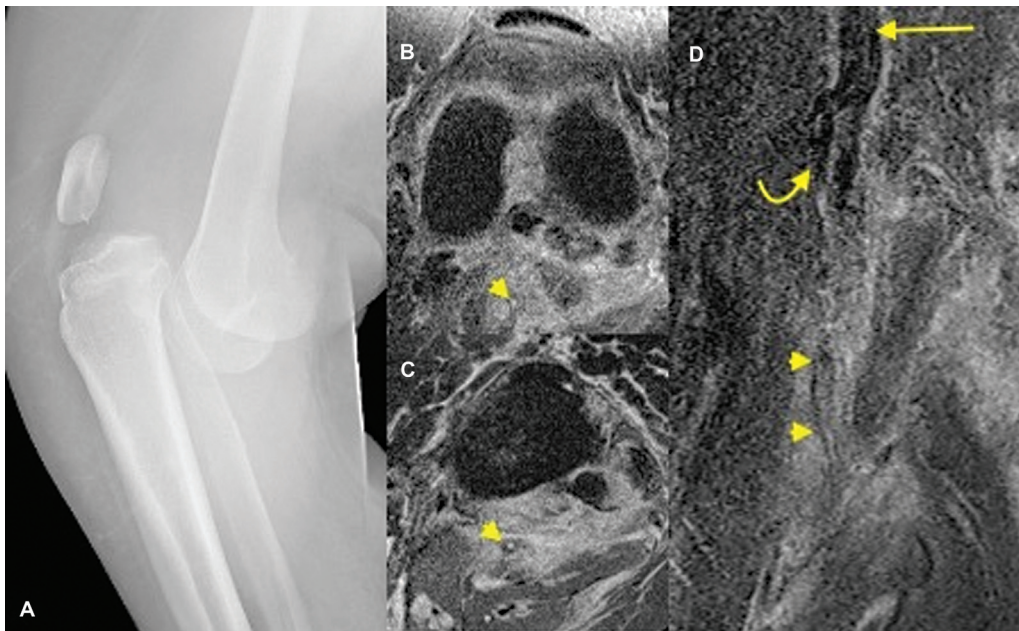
Popliteal artery thrombosis following injury related to the posterior knee dislocation: The lateral knee radiograph (A) showing high-grade posterior knee dislocation. T2-fat-suppressed (T2-FS) axial images at distal femoral condyle (B) and proximal tibiofibular joint (C) showing loss of popliteal artery flow void (arrowheads) consistent with thrombosis. The coronal T2-FS image (D) showing a long-segment popliteal artery thrombosis (arrowheads) compared with a normal popliteal artery (curved arrow) in the popliteal fossa apex. The popliteal vein (straight arrow) is also patent.
